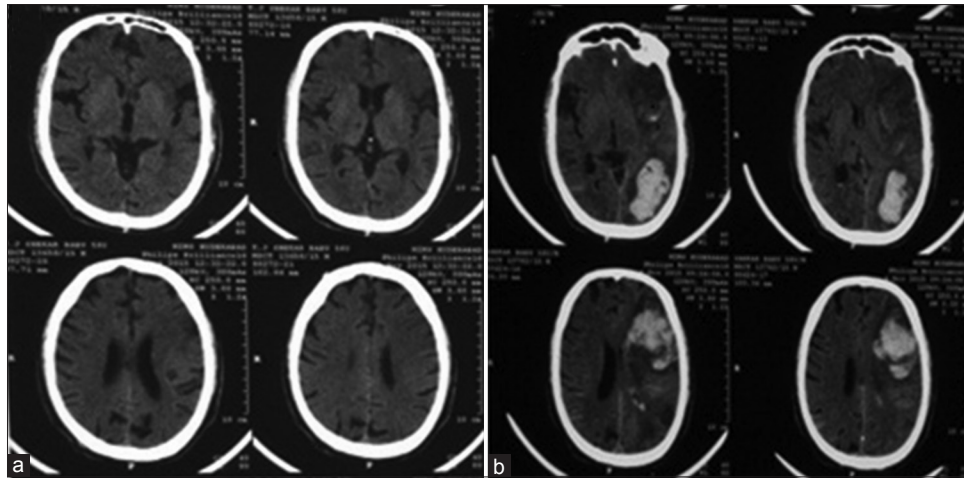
Computed tomography scan brain of 58-year-old patient showing left middle cerebral artery territory infarct (a) with postthrombolysis hemorrhage in the same region (b)
